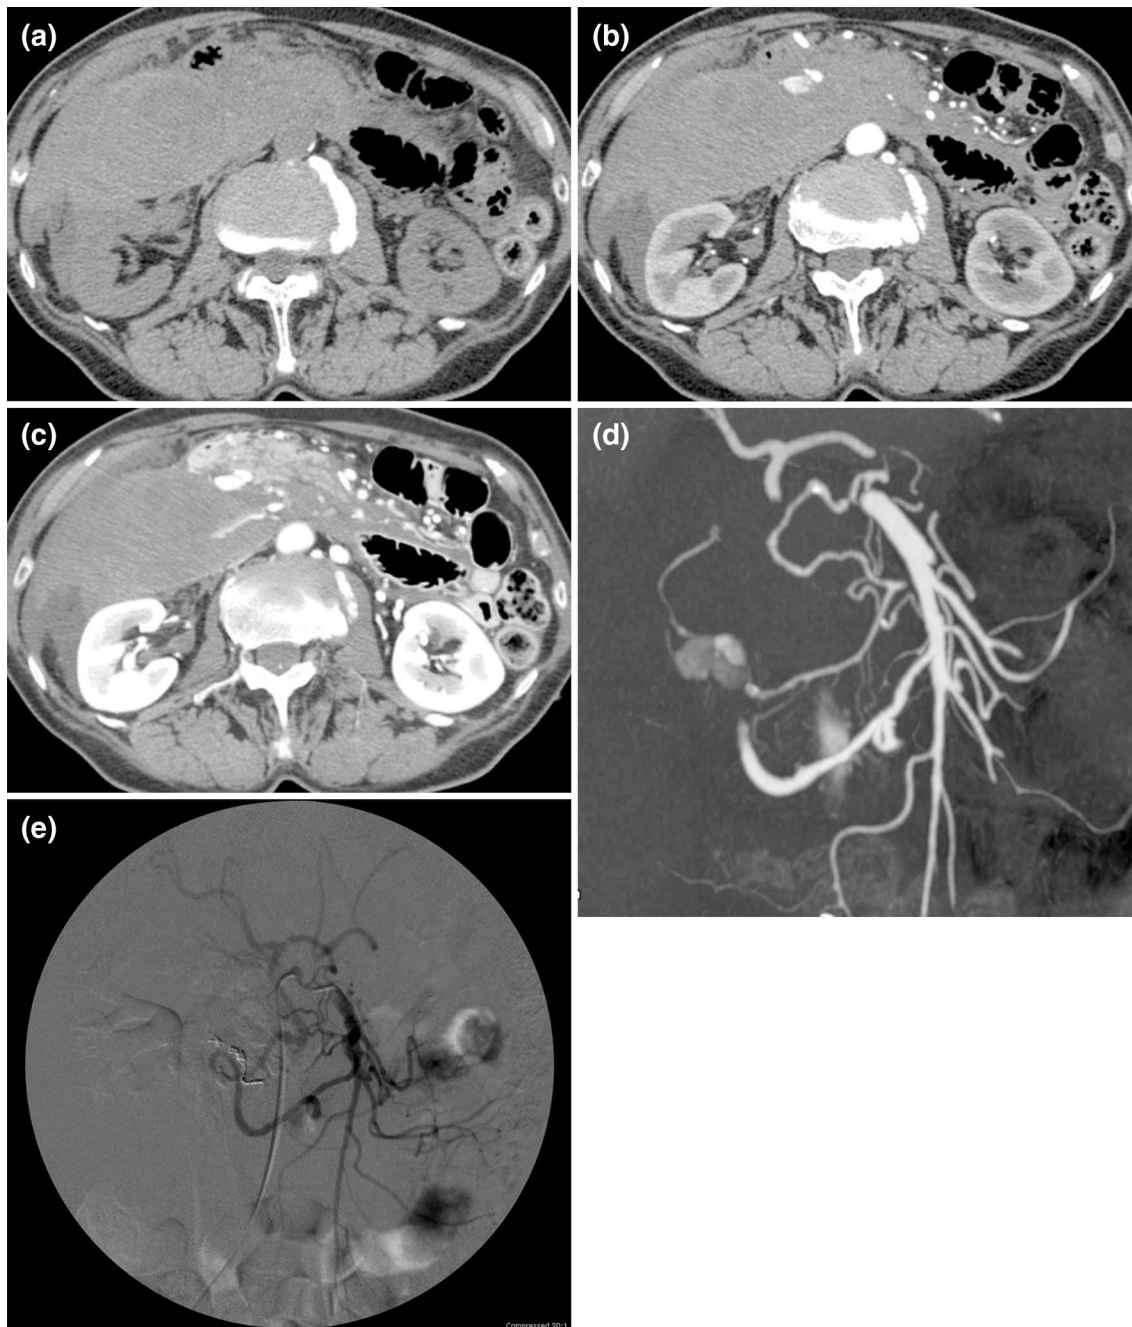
A 75-year-old woman submitted to chronic antiplatelet treatment suffering severe epigastric and right flank pain. The CT scan shows a heterogeneously hyperdense retroperitoneal collection with contextual fluid–fluid levels (a). The axial CT scan acquired in the arterial phase demonstrates signs of active bleeding (b) with evidence of the so called “*signal flare*” sign (c). MIP reformation image
